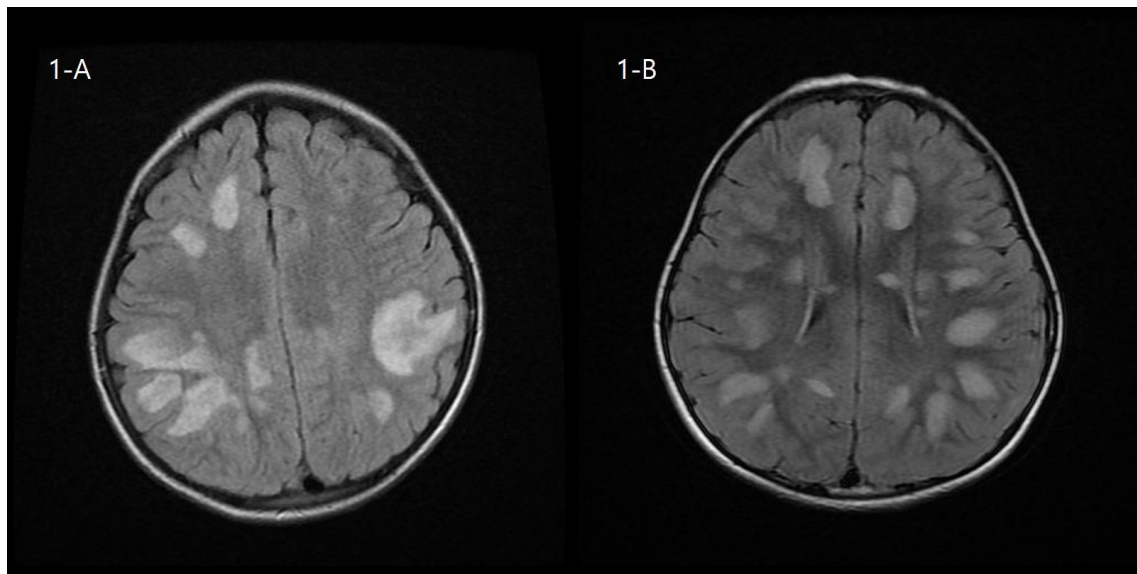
The T2 FLAIR show polyfocal lesions in brain MRI of ADEM patient 1 who showed MOG antibodies positive (A), similar multiple and large lesions are shown in patients 19 who is negative for MOG antibodies (B). FLAIR, fluid-attenuated inversion recovery; ADEM, acute disseminated encephalomyelitis; MRI, magnetic resonance imaging; MOG, myelin oligodendrocyte glycoprotein.
